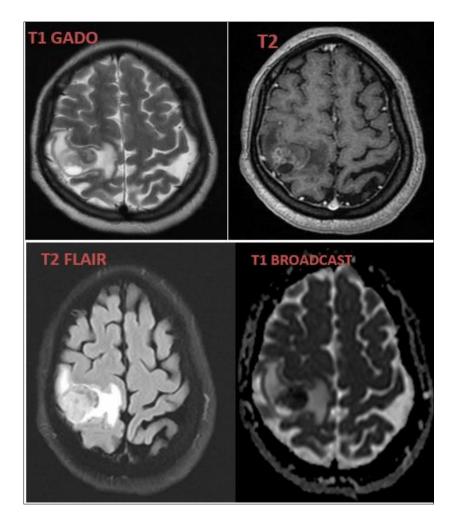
MRI images of an intra-axial lesion process of the right parietal convexity with heterogeneous signal (B), enhanced peripherally after injection (A) associated with annular perilesional edema with focal erasure of cortical sulci (C), absence of diffusion abnormality (D)
